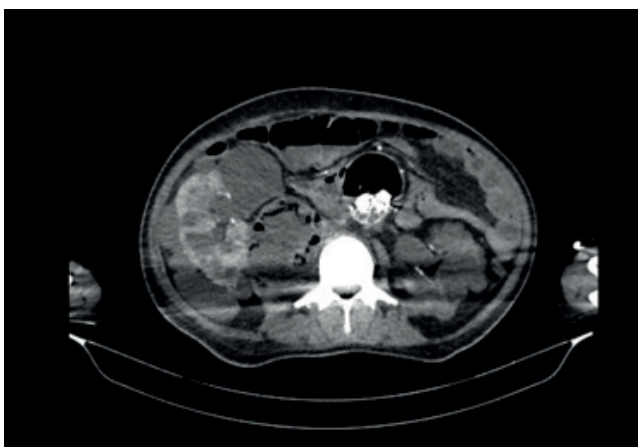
Contrast-enhanced abdominal CT scan performed at the patient's last admission revealed abscess formation in the right psoas and massive air and fluid level in the true lumen of the aorta.
